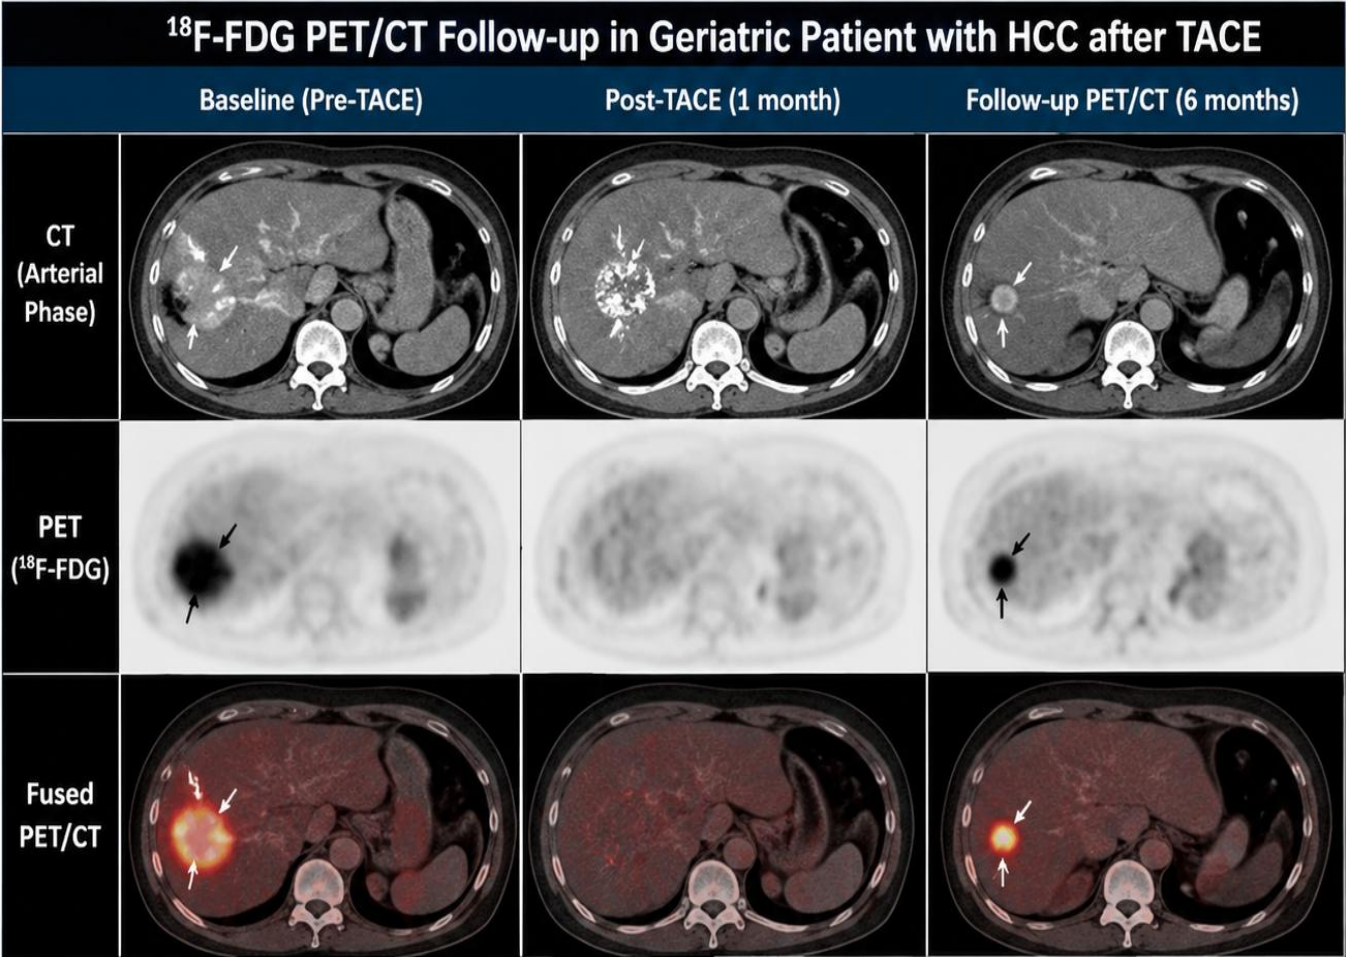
Serial 18F-FDG PET/CT Demonstrating Metabolic Response and Subsequent Recurrence of Hepatocellular Carcinoma Following Transarterial Chemoembolization
